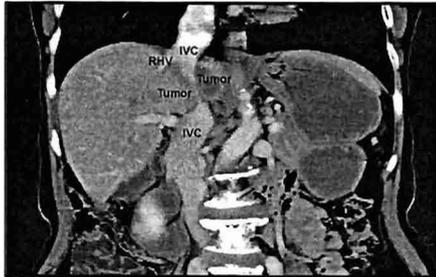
Coronal view of CT abdomen revealed mass involving segment I, VI, VII and IVC.
